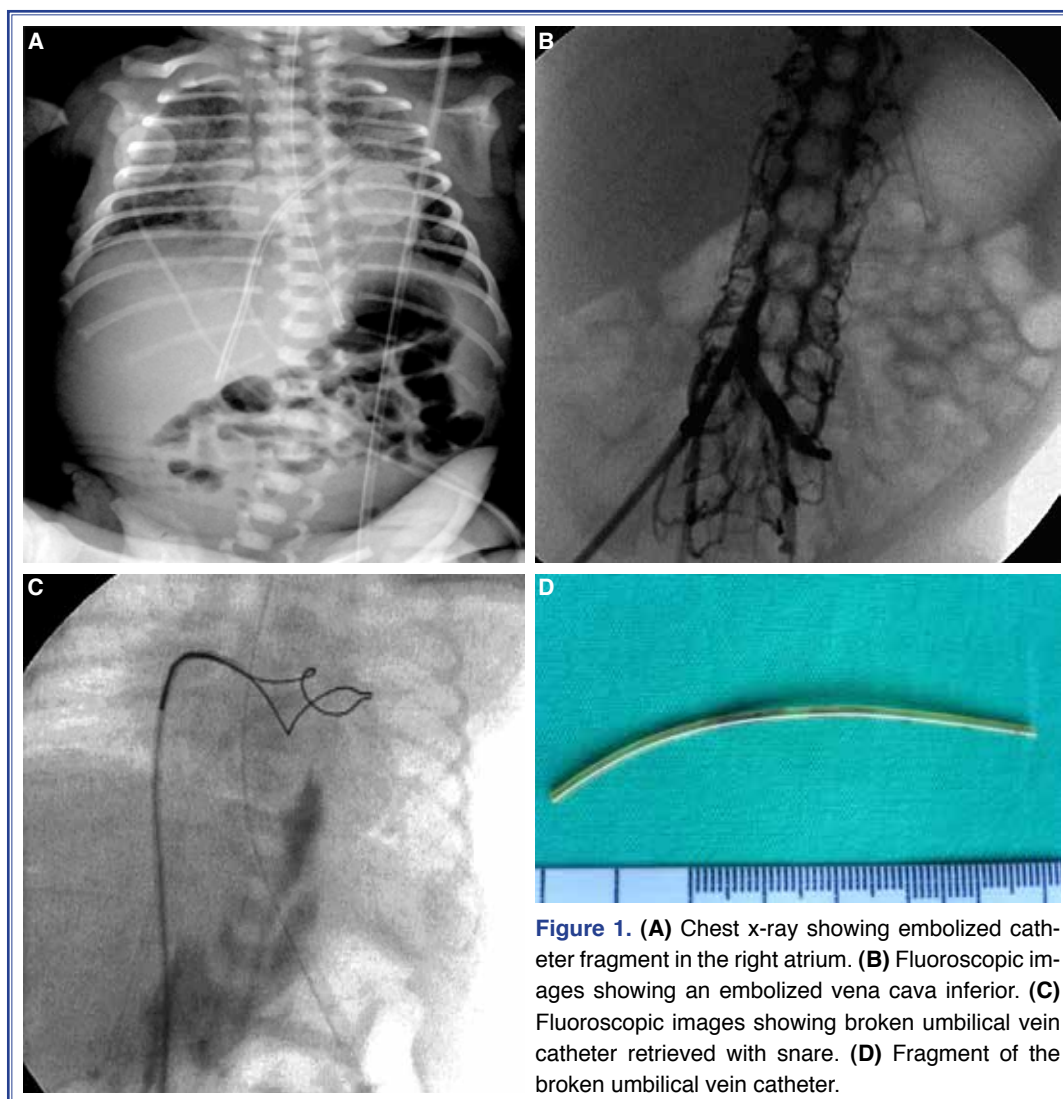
(A) Chest x-ray showing embolized catheter fragment in the right atrium. (B) Fluoroscopic images showing an embolized vena cava inferior. (C) Fluoroscopic images showing broken umbilical vein catheter retrieved with snare. (D) Fragment of the broken umbilical vein catheter.
